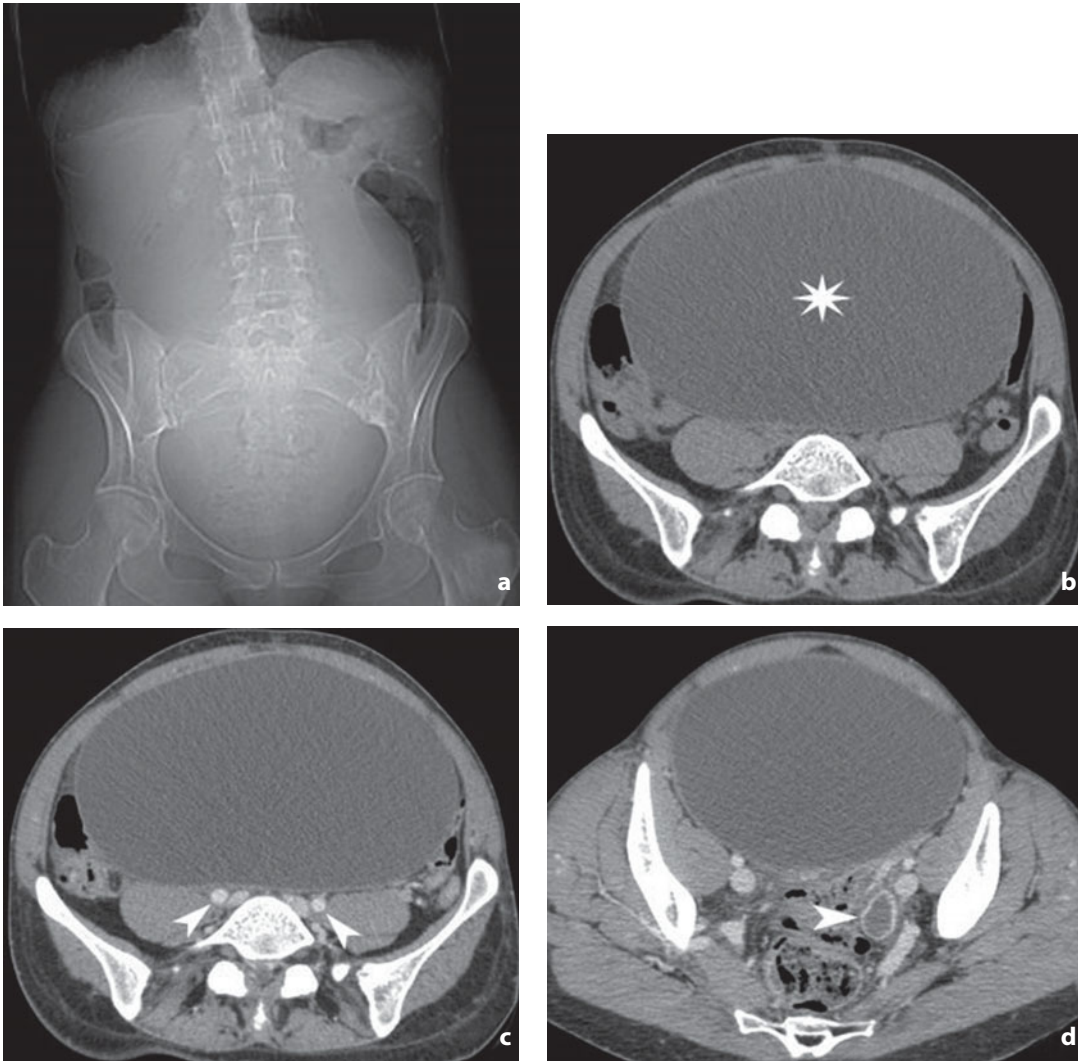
Plain film radiography and computed tomography. Right serous cystadenoma and left corpus luteum cyst. a The anteroposterior view of the plain abdominal film shows poorly represented bowel loops with greater opacity in the central abdominal quadrants and imprint and lateral displacement of the visible tracts of the large intestine. b Nonenhanced CT shows large oval expansive abdominal-pelvic lesion (*asterisk*) with sharp regular margins, thin walls and fluid-density content compressing and displacing the adjacent structures. c After contrast medium administration the image shows no areas of abnormal enhancement, nodules or septa and better demonstrates the relations with the iliac vessels (*arrowheads*). d A more caudal scan of the same mass shows the left ovary, in which an oval-shaped lesion (*arrowhead*) is visualized with fluid content and intensely enhancing walls: corpus luteum cyst
